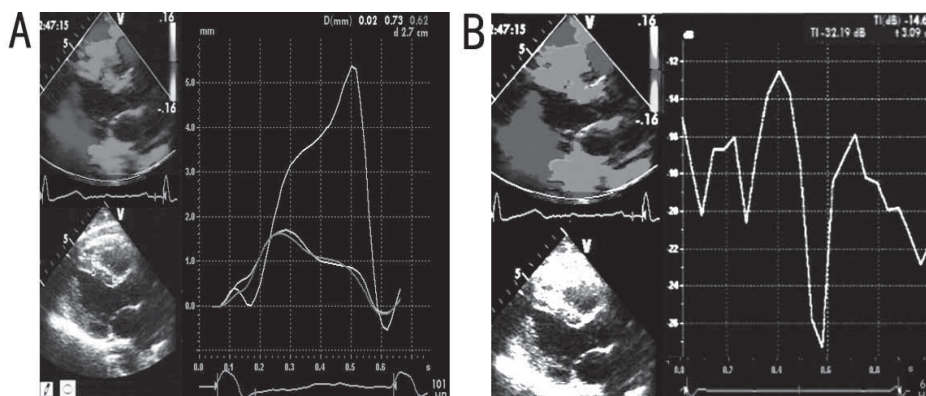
Measurement methods of regional myocardial displacement and grayscale intensity. The image was obtained from the parasternal long-axis view of the heart in a normal subject. A. peak displacement determined by displacement curve using tissue tracking; B. maximal and minimal grayscale intensity in the cardiac cycle determined by grayscale intensity curve using videodensitometric analysis.
